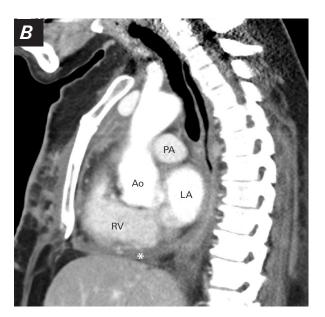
Computed tomogram after pericardiocentesis with reduced effusion (asterisk) in A) coronal and B) sagittal planes.
